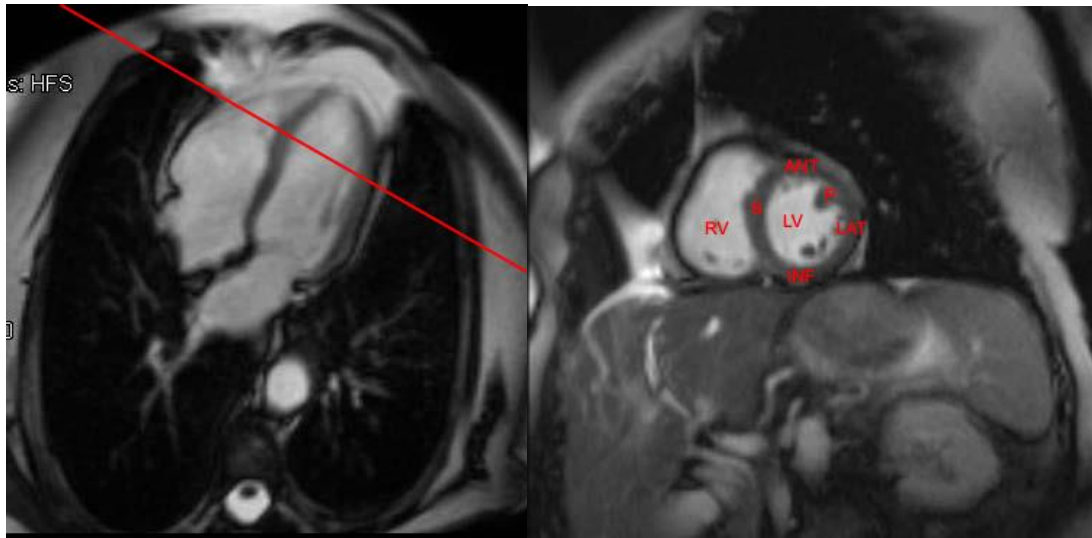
A short axis view of a cardiac MRI. The image on the right is obtained through the plane represented by the red line of the left. ANT = Anterior wall, INF = Inferior wall, LAT = Lateral wall, LV = Left Ventricle, P = Papillary muscle, RV = Right Ventricle, S = Septum
